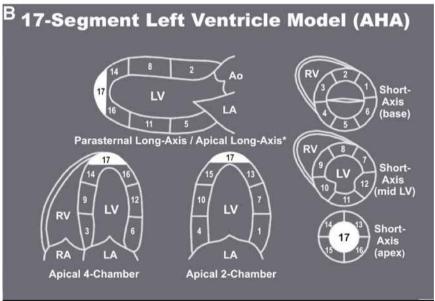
The American Society of Echocardiography (ASE) issued a 16-segment left ventricle model for wall motion assessment. The American Heart Association's (AHA) 17-segment model has an additional apical segment "cap" added to harmonize left ventricular segment nomenclature with nuclear cardiology and cardiac magnetic resonance imaging. (A) A 16-segment model of left ventricular segments (ASE). (B) A 17-segment model of left ventricular segments (AHA).
